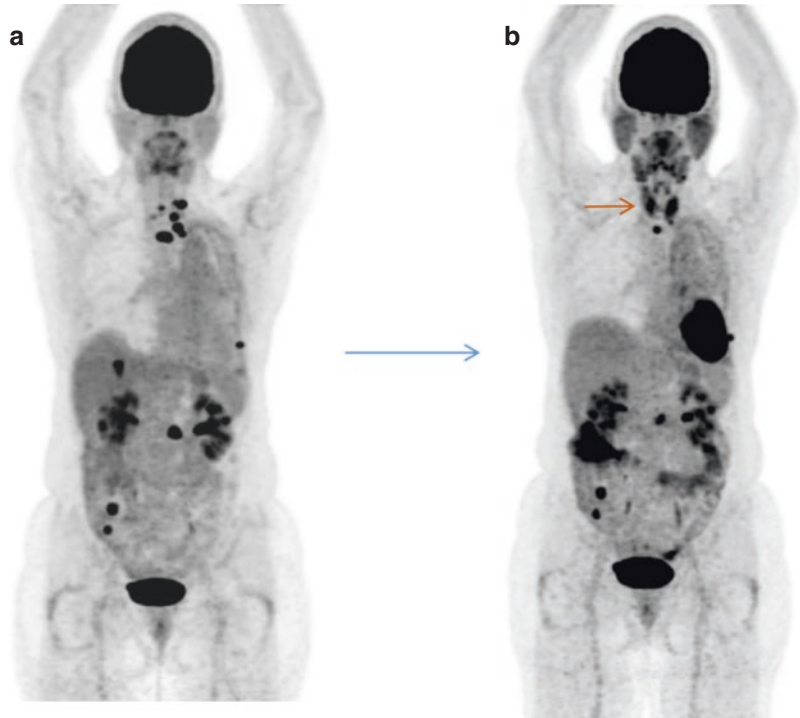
^{18}F -FDG PET/CT images in a woman with metabolically active melanoma. Axial CT, PET, fused and MIP images obtained prior to (a) and following (b) ipilimumab and nivolumab therapy show complete response. The
